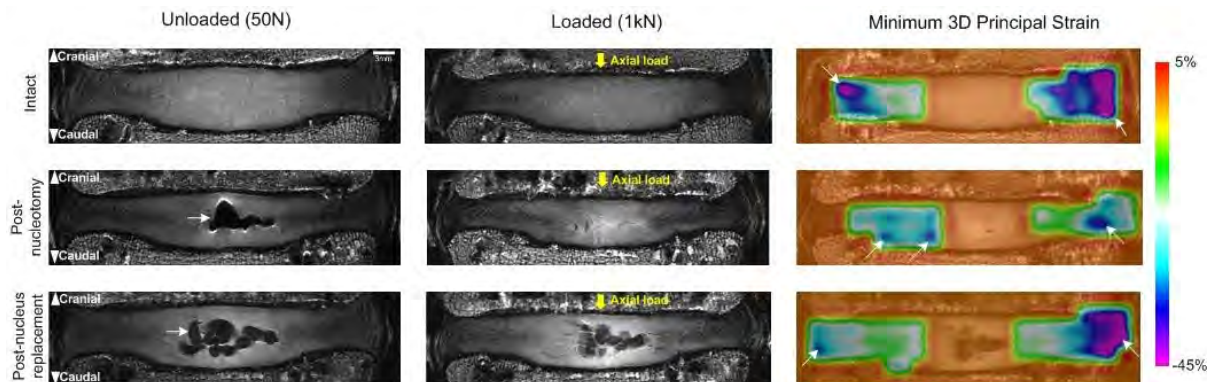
9.4T MRI coronal plane view of intervertebral disc in intact, post-nucleotomy and post-nucleus replacement in both unloaded and loaded conditions along with the minimum 3D principal strain maps. The arrow in the unloaded post-nucleotomy MRI indicates the cavity formed in the disc after nucleus removal. The arrow in the bottom left unloaded state MRI indicates the nucleus replacement device. The arrows on the strain maps indicate location of peak strain.
